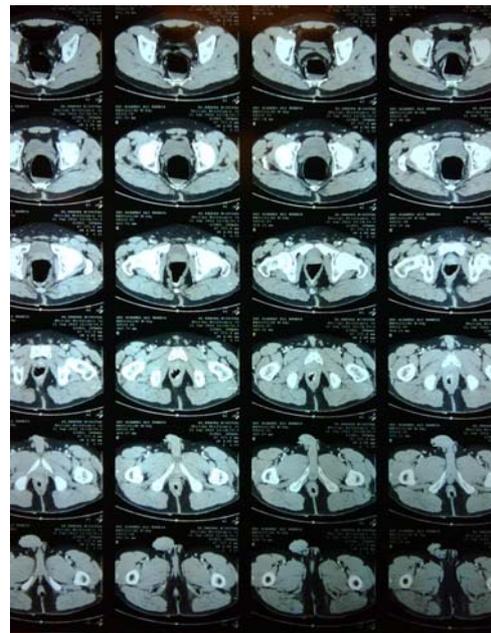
Whole colon CT.
